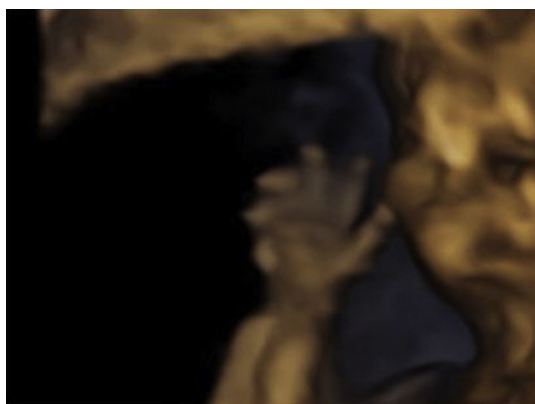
Three-dimensional ultrasound with surface rendering mode showing the proboscis and polydactyly of the right hand.
